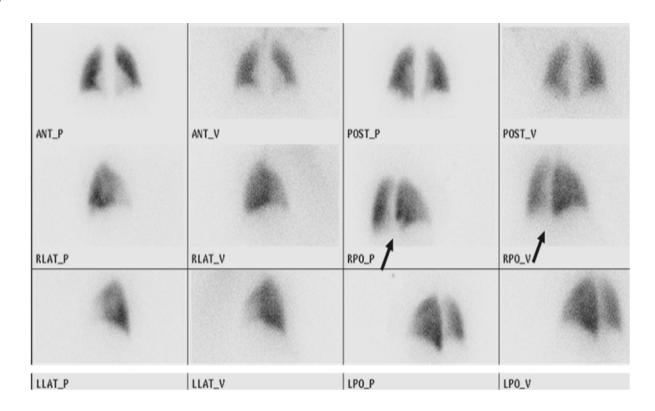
Case Three (Below V/Q SPECT images)
